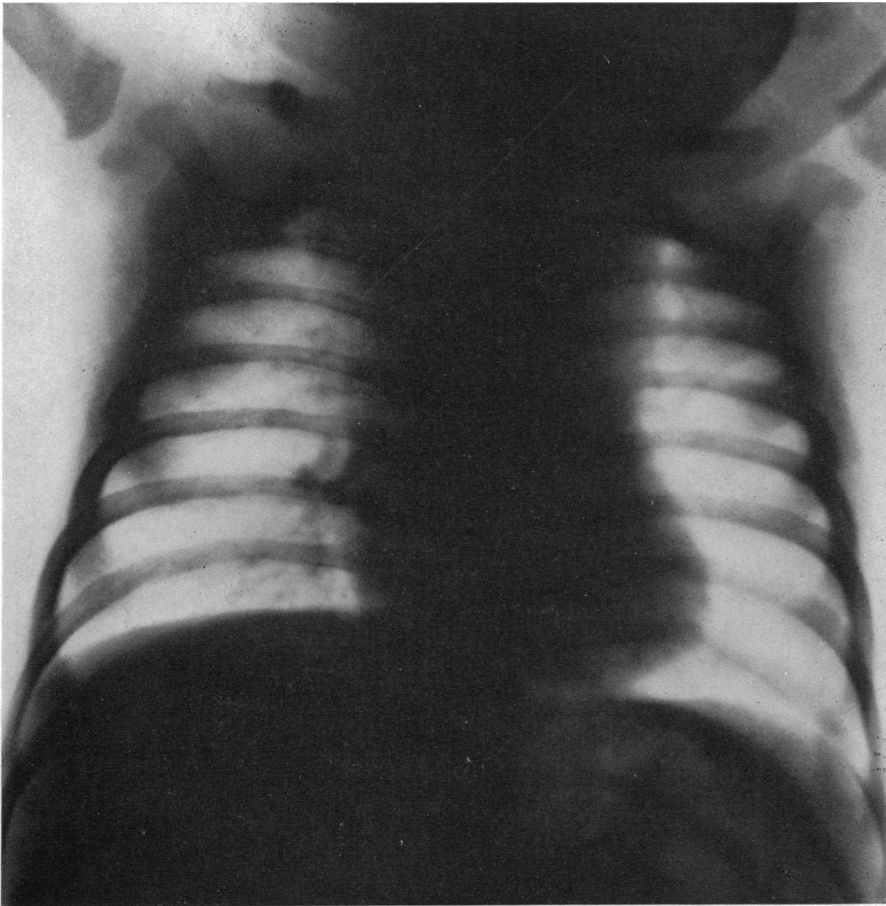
Skiagram of the infant's chest at the time it was first seen. Note the enormous widening of the mediastinal shadow which was misinterpreted as being due to a greatly enlarged thymus. X-ray treatment did not reduce the size of this shadow or cause the disappearance of her symptoms.
